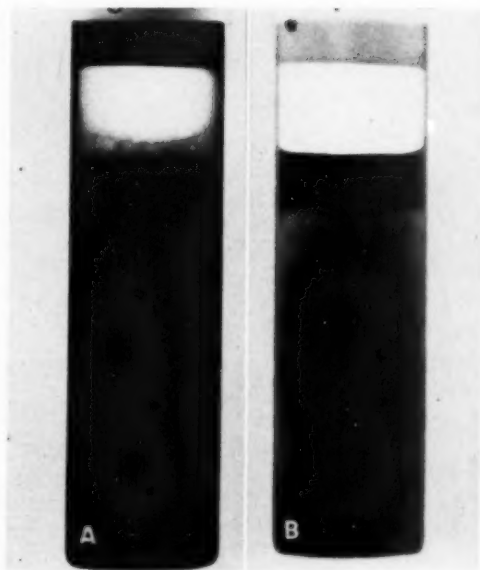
A. Roentgenogram, *in vitro*, of the mixture of thorotrast and blood in the circulation as used in the experiments. This film was made immediately after the thorotrast had been injected into the blood. The contrast-filled blood shows a homogeneous shadow. B. Roentgenogram, *in vitro*, five hours after the injection, when sedimentation of the blood corpuscles has occurred. The thorotrast is seen to be mixed both with the red and white corpuscles as well as with the plasma.
